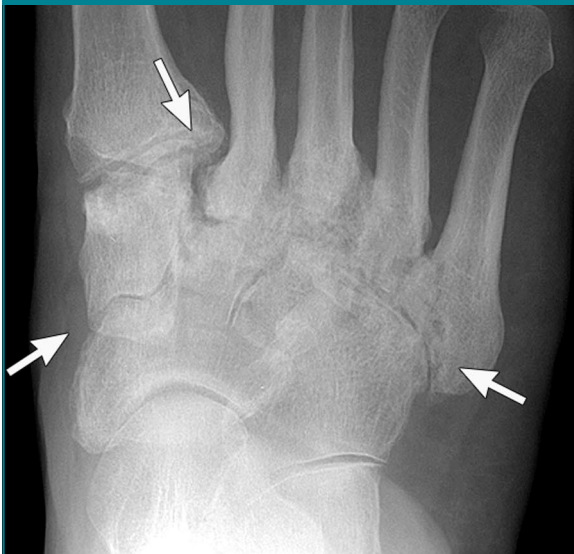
Neuropathic joint. (a) Anteroposterior and (b) lateral foot radiographs show joint space narrowing, sclerosis, subchondral cyst, and osteophyte formation (arrows). Note plantar navicular tilt and pes planus.
